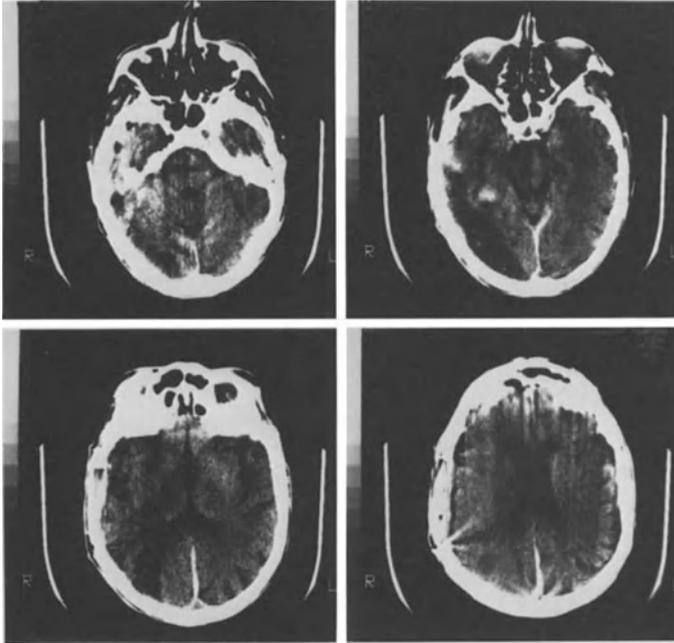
K.M., 91 years old, postoperative CT
